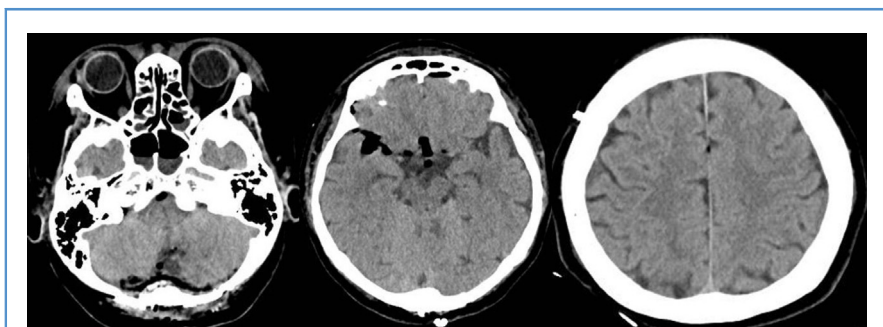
Postoperative computed tomography scan showed air but no blood in the basal cisterns.
